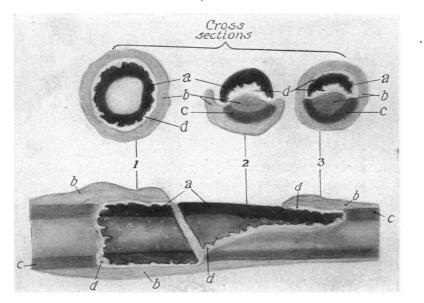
Sketch of X-ray of old infected fracture showing atrophy of surviving cortex, involucrum formation and two sequestra with well-preserved fracture lines and external surfaces that are eroded where adjacent to and little or uneroded where remote from living bone; a, dead bone; b, new bone; c, atrophied old bone; d, zone of demarcation. Cross sections show sequestra with erosion along I, external surface; 2, internal surface; and 3, both internal and external surfaces. Differences in density well shown.
